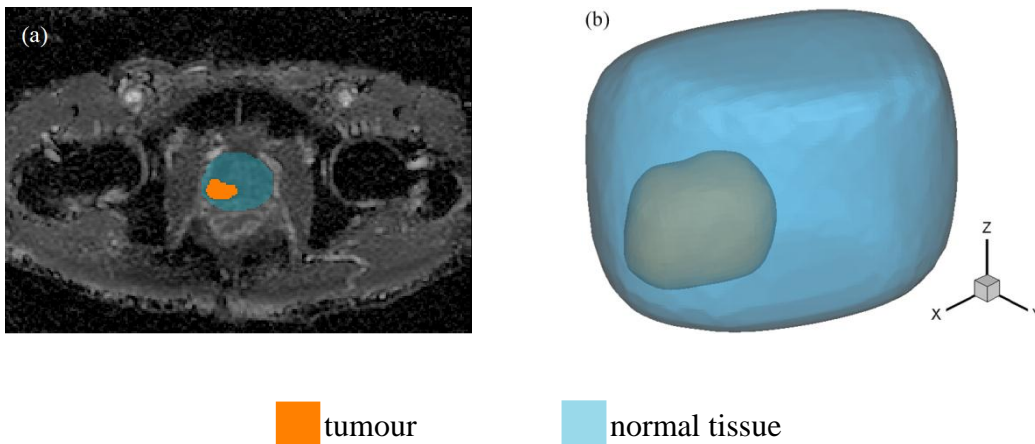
Model geometry: (a) MR image of the prostate tumour and its surrounding tissue; (b) the reconstructed 3-D geometry.
